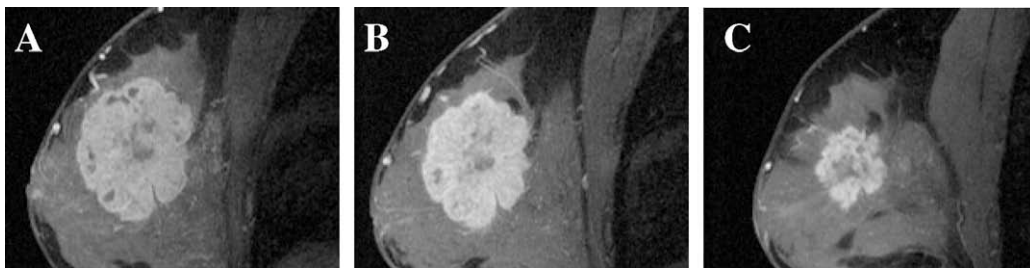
Monitoring response to neoadjuvant chemotherapy with MRI. (A) and (B) represent the pre-treatment and post-treatment MR images of a patient who had a complete response. (C) and (D) represent pre-treatment and post-treatment images from a patient whose tumour underwent a partial response. (E) and (F) demonstrate progressive disease despite neoadjuvant chemotherapy.
